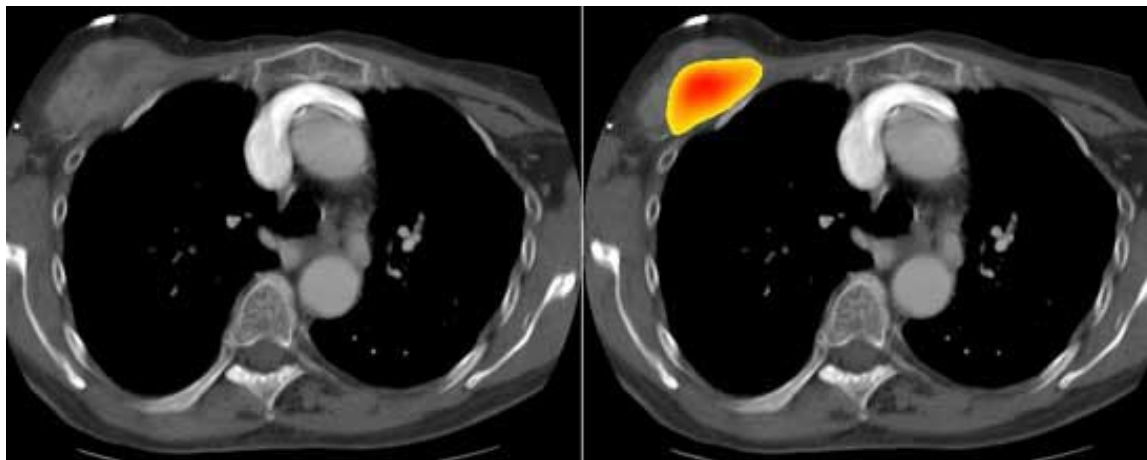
Note the PET-CT fusion in this case of breast cancer courtesy of Jenna Murphy PET in breast imaging (Figure 4)
